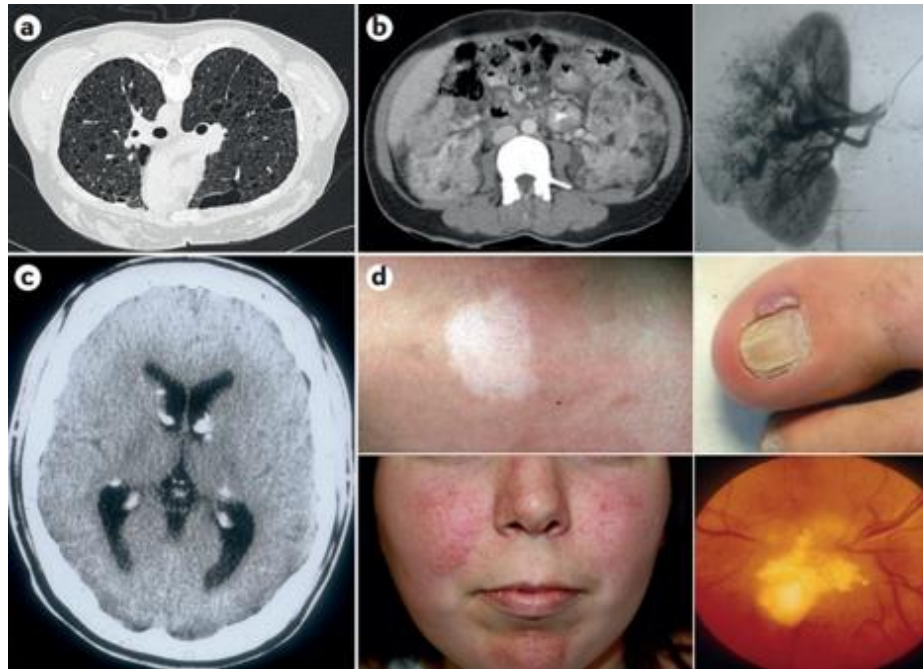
Manifestations of Tuberous Sclerosis Complex in the skin, kidney, and lungs. This figure shows TSC in a clinical context as (a) a chest scan of lymphangiomyomatosis (LAM). Renal manifestations of TSC (angiomyolipomas) are depicted by an (b) abdominal CT scan (left) and a renal angiogram (right). TSC in the brain is shown by (c) a CT scan of subependymal nodules. Skin manifestations of TSC are depicted by (d) four panels showing hypomelanotic macules (top left), subungual fibroma (top right), facial angiofibroma (bottom left), and retinal hamartoma (bottom right) Figure adapted from (Henske et al., 2016).
